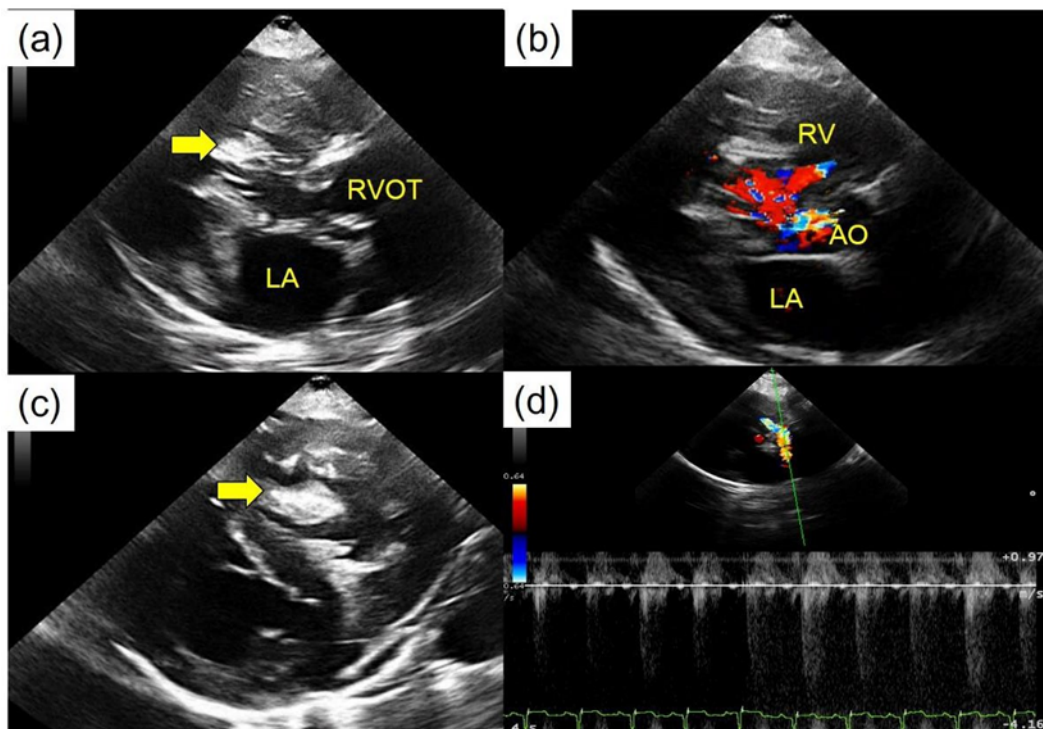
Echocardiogram showing (a) the presence of hyperechoic band in the right ventricle (RV) which inserts below the right ventricular outflow tract (RVOT). Note the severe RV hypertrophy. (b) The color Doppler showing right communication between the left ventricle and RV through membranous ventricular septal defect. (c) The short axis view demonstrating the hyperechoic band and the RV hypertrophy. (d) On Doppler study, there was a high pressure gradient (3.27 m/s) across the stenotic RVOT, indicating pulmonic stenosis.
